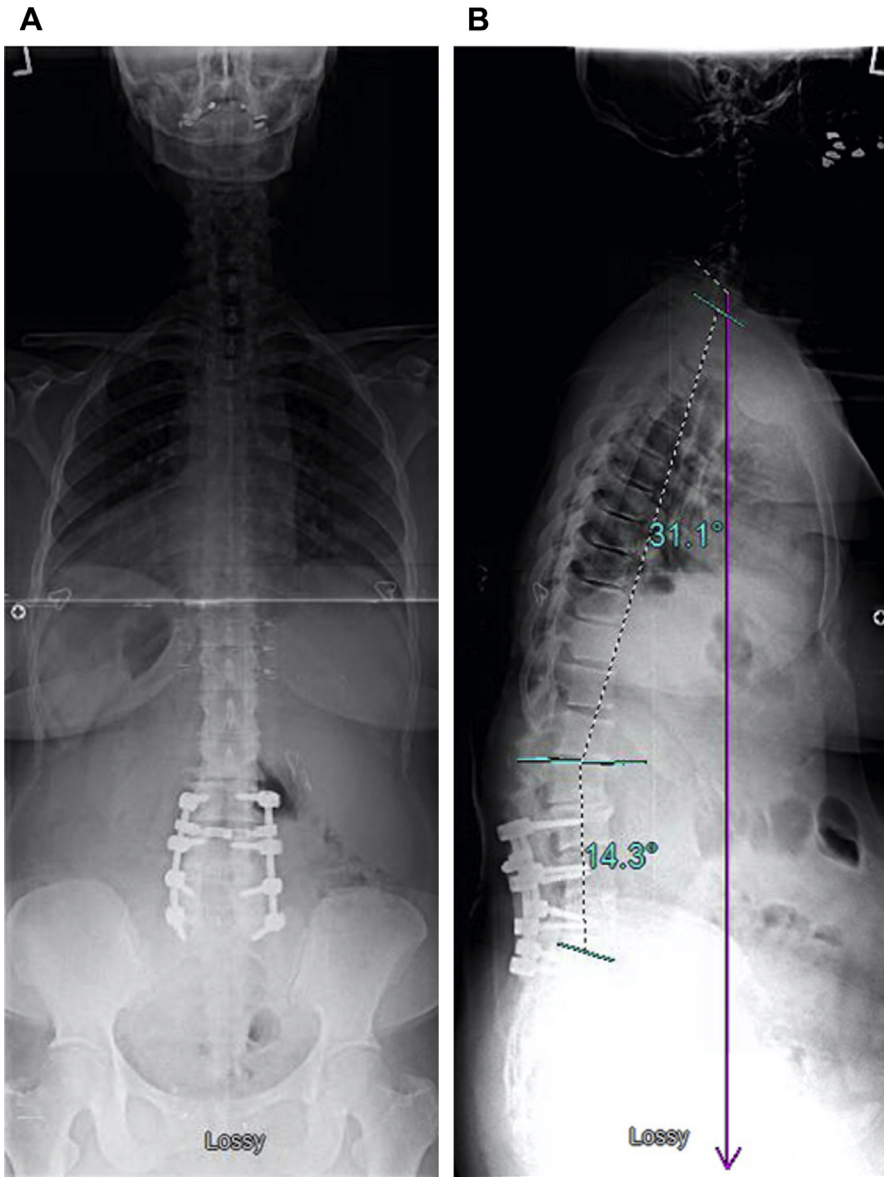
The 36-in standing posteroanterior (A) and lateral radiographs (B) of a patient with sagittal imbalance.
